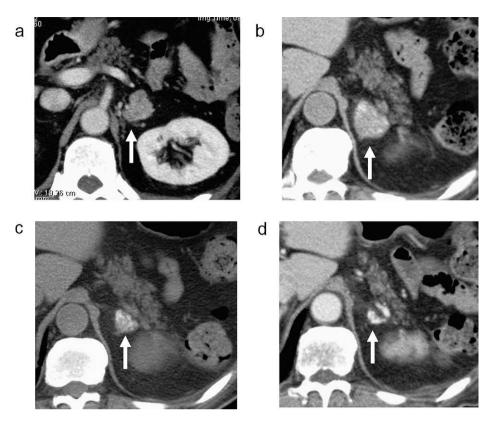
Computed tomography (CT) scan of left adrenal gland. (a) Left adrenal gland metastasis was detected in 2007. (b) Regrowth of the resected adrenal metastasis in 2008. (c) Cetuximab therapy achieved significant reduction of metastasis in 2010. (d) The tumor was replaced by calcification after radiotherapy in 2011.
